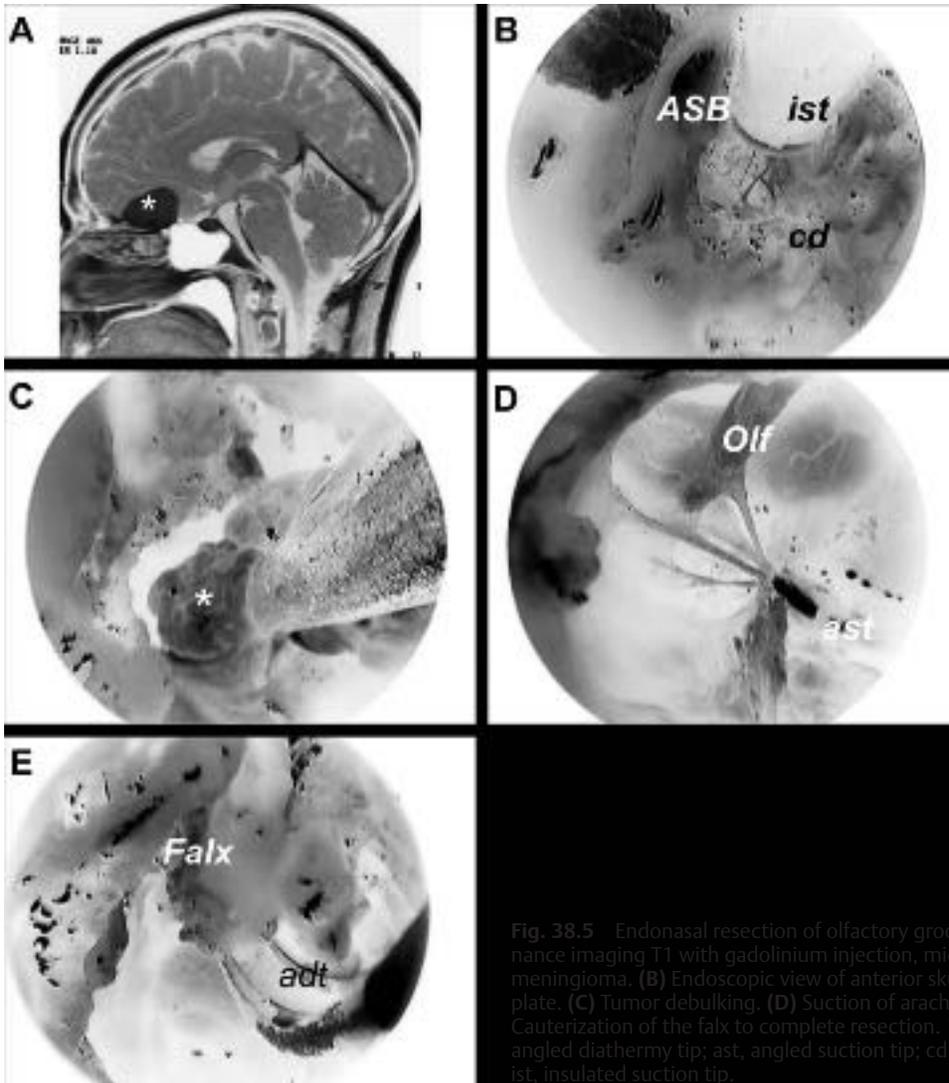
Endonasal resection of olfactory groove meningioma. (A) Magnetic resonance imaging T1 with gadolinium injection, midsagittal plane reveals olfactory groove meningioma. (B) Endoscopic view of anterior skull base postremoval of cribriform plate. (C) Tumor debulking. (D) Suction of arachnoid adjacent to neural structures. (E) Cauterization of the falx to complete resection. *, tumor; ASB, anterior skull base; adt, angled diathermy tip; ast, angled suction tip; cd, cauterized dura; olf, olfactory nerve; ist, insulated suction tip.
